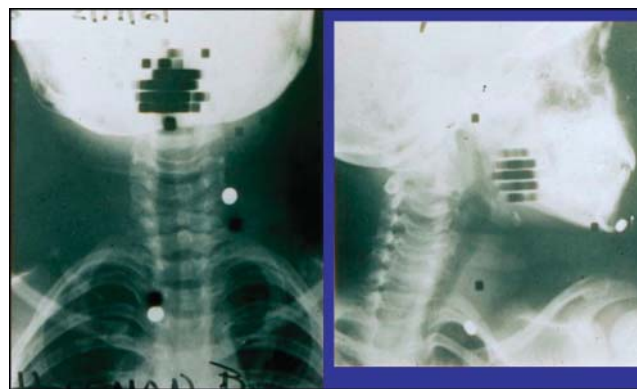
A 1961 rectilinear scan performed with ^{131}I and superimposed over a radiograph.
